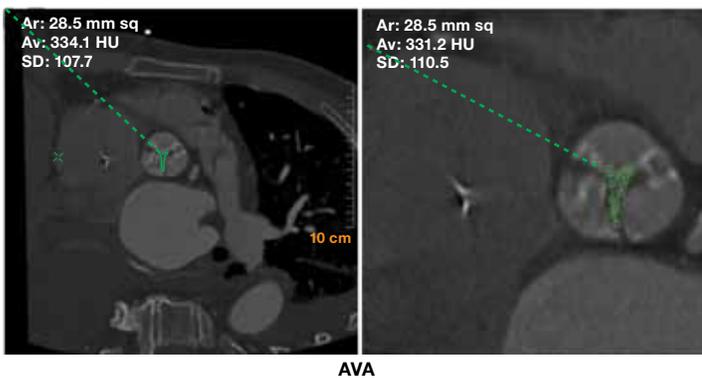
Aortic valve area (AVA) by CTA. Computed tomography angiographic double-oblique transverse images of the aortic valve at the level of the cusp tips during systole when the valve is maximally opened (typically 30%-40% of RR-interval). The smallest aortic valve area is identified by scrolling up and down through the dataset. The AVA is then measured by planimetry. In this patient, planimetry reveals critical aortic stenosis with only a slit-like opening. The extent of leaflet calcification can also be quantified on either the contrast (above) or non-contrast CT study.
